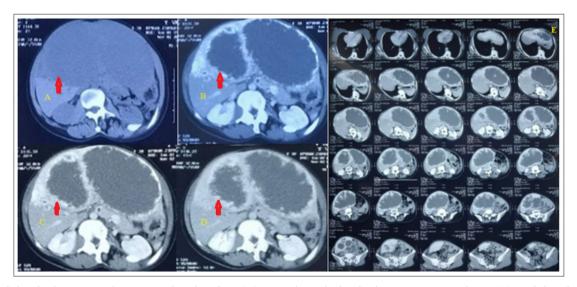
Abdominal Computed Tomography Showing: (A) Hypodense lesion in the non-contrast phase, (B) Peripheral enhancement in arterial phase, (C) Central filling in venous phase and (D) delayed phase. (E) Images of hemangiomas in the venous phase.
